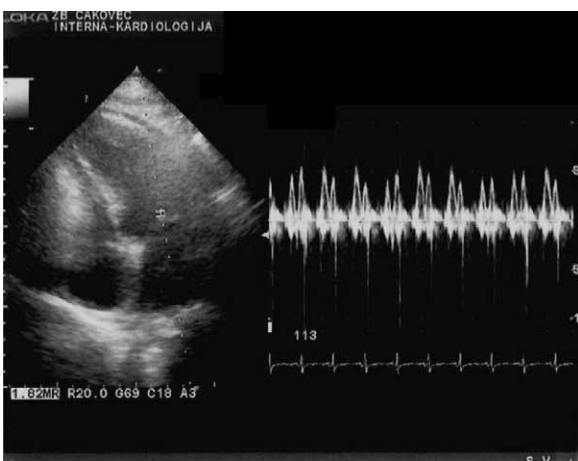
Doppler finding in constrictive pericarditis. Pulsed-wave Doppler recording of flow velocity measurements revealed exaggerated respiratory variation (more than 25%) in both mitral inflow velocity.
